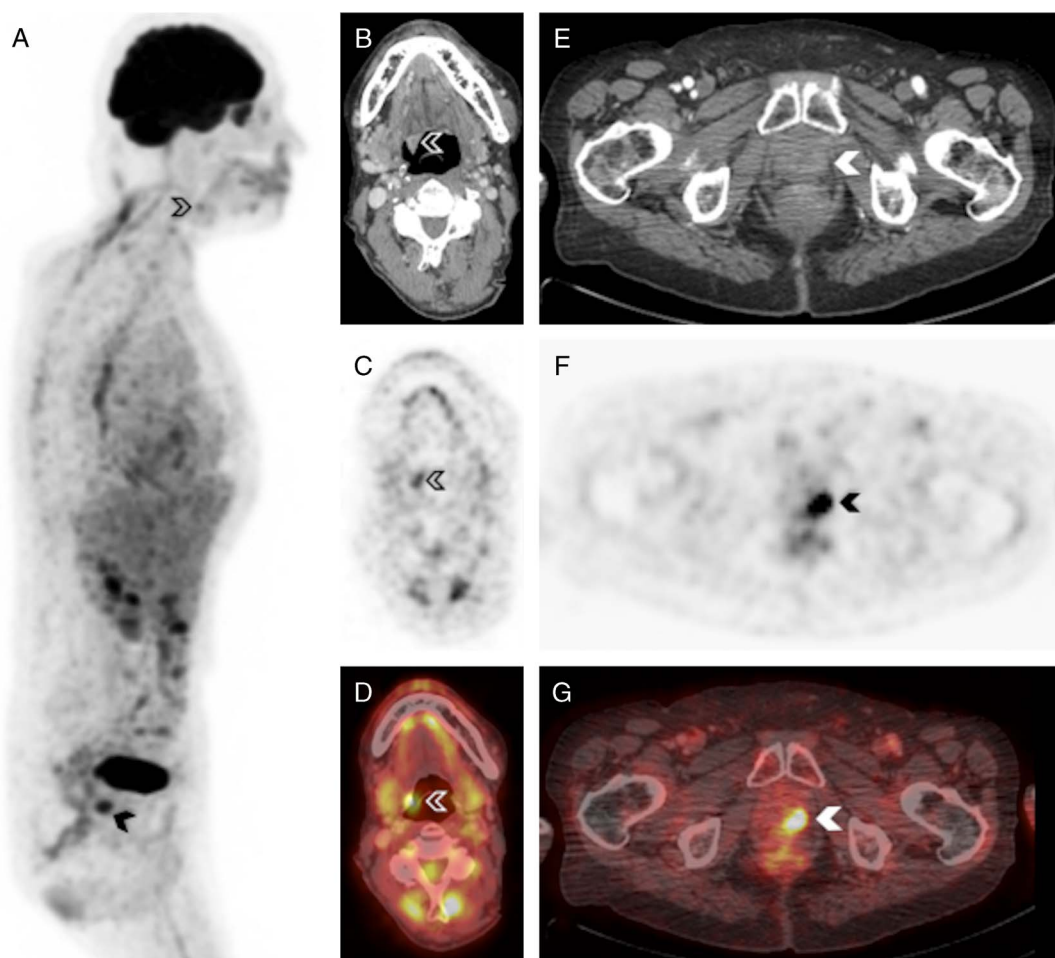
^{18}F -FDG PET/CT was obtained for further SCC characterization and staging, with PET images acquired 81 minutes after injection of 8.6 mCi (318.2 MBq). Axial PET (C) images demonstrated focal right oropharyngeal hypermetabolism (open arrowhead; SUVmax 3.4), corresponding to known tongue base SCC visualized on sagittal MIP PET (A), CT (B), and fused PET/CT (D). Additionally, MIP PET (A), CT (E), PET (F), and fused PET/CT (G) showed prostate gland focal hypermetabolism (solid arrowhead), compatible with known prostate cancer. No definite additional FDG avid metastases were identified. Given the patient's cardiac comorbidities, targeted radiation therapy was favored over chemotherapy, and the patient is currently undergoing stereotactic body radiation therapy. While ^{18}F -fluciclovine is approved for PET/CT imaging of suspected recurrent prostate cancer,³ it is also being evaluated for cerebral glioma^{4,5} and has shown promise in breast cancer diagnosis and treatment response.⁶⁻⁸ Tracer avidity has been described in several other malignancies including lung cancer,⁹ papillary renal cell carcinoma,¹⁰ colon cancer, rectal cancer, follicular lymphoma,^{11,12} hepatocellular carcinoma,¹³ and melanoma.¹⁴ Finally, uptake is reported with benign entities including meningioma, osteoid osteoma, and pituitary adenoma.¹² Fluciclovine is a non-natural amino acid with cellular uptake driven by ASCT2 and LAT1, sodium-dependent amino acid transporters³ that play an important role in pathogenesis of many malignancies. ASCT2 and LAT1 overexpression has been described in tongue and laryngeal SCC.^{15,16} This case demonstrates that head and neck SCC can uptake ^{18}F -fluciclovine, and highlights the importance of investigating regions of unexpected radiopharmaceutical uptake. Moreover, it suggests a potential application of this radiopharmaceutical in detecting head and neck SCC.
